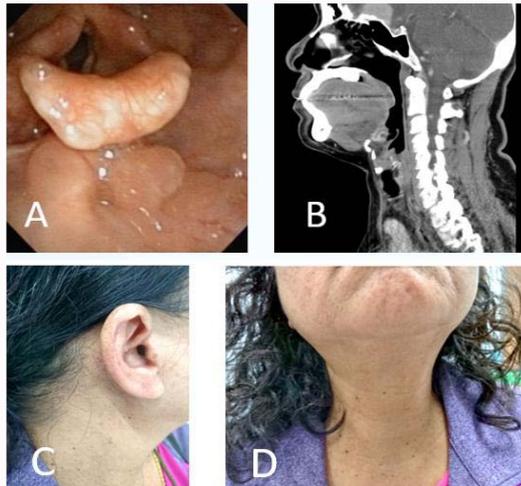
Post operative follow up examinations. A) Post-operative flexible laryngoscopic view showed normal tongue base with lingual tonsils. Sagittal CT scan showed no tumor recurrence at 2-year follow up, C) The hidden post aural scar is almost invisible from lateral view of the face. D) There is no visible scar on the anterior neck after robotic esthetic neck surgery without tracheostomy.
